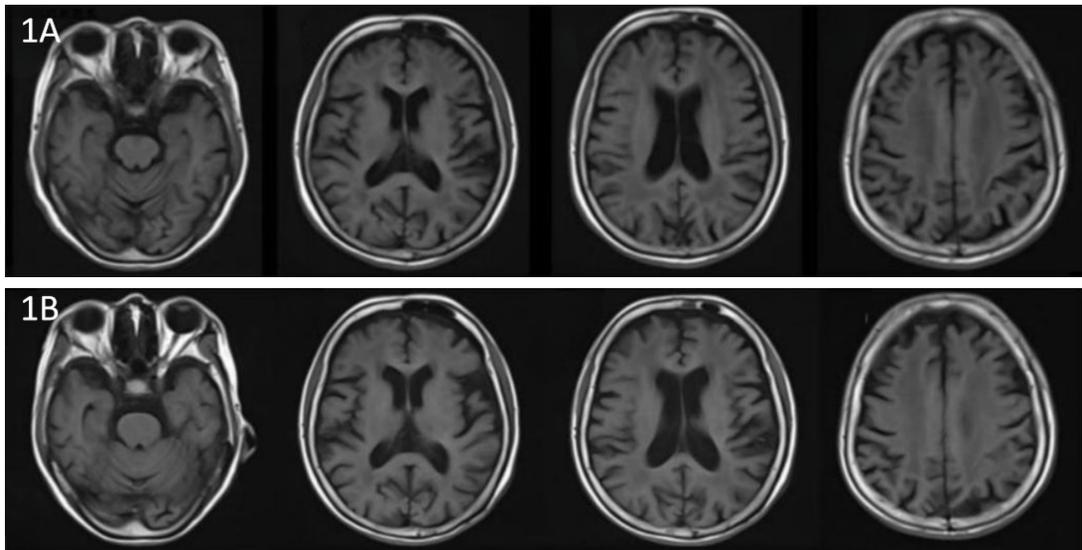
T1 FLAIR images demonstrating progressive cerebral atrophy. (A) Baseline image (2023) showing widened cerebral sulci and periventricular white matter hypointensities. (B) Follow-up image (2024) revealing further sulcal widening and ventricular enlargement, consistent with advancing cerebral atrophy.
